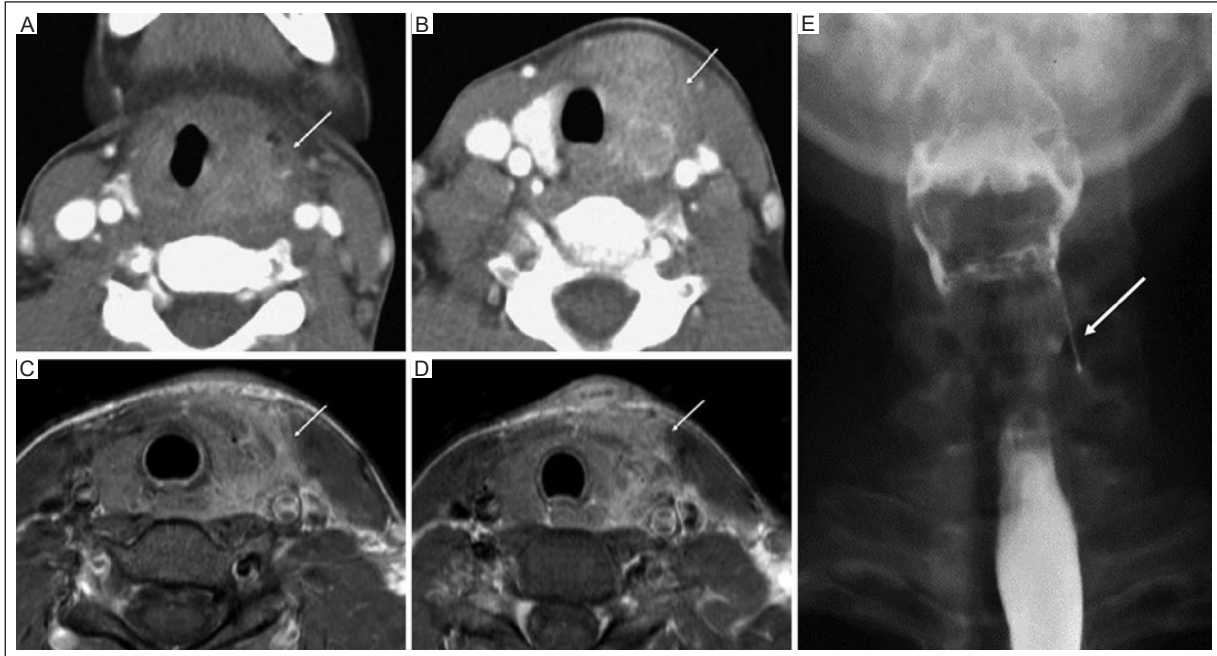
Fourth branchial cleft anomaly. A-B: axial contrast-enhanced CT, and C-D: axial T1-weighted post-contrast MRI show diffuse inflammatory changes with edema and contrast enhancement within and around the left thyroid lobe (arrows). There are also small multifocal foci of peripherally enhancing hypodense abscesses in the region. Findings are consistent with left-sided thyroiditis. E: coronal video fluoroscopic swallow study depicts a thick linear area of ingested contrast passing through the left pyriform sinus towards the left thyroid lobe (arrow), consistent with the fistulous/sinus tract. Findings are consistent with a left-sided fourth branchial cleft anomaly.
